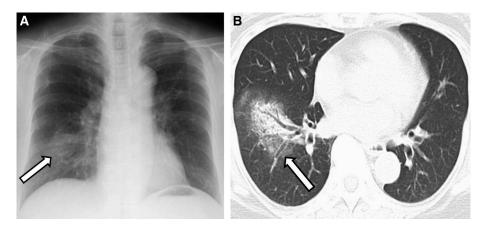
Bacterial pneumonia. Bacterial pneumonia in a 65-year-old woman with fever, cough, and sputum who had received steroid treatment for 1 year. (A) Chest radiograph and (B) computed tomography, showing unilateral and segmental focus of consolidation (arrows). Diagnosis of bacterial pneumonia is based on positive urine *Streptococcus pneumoniae* antigen.
